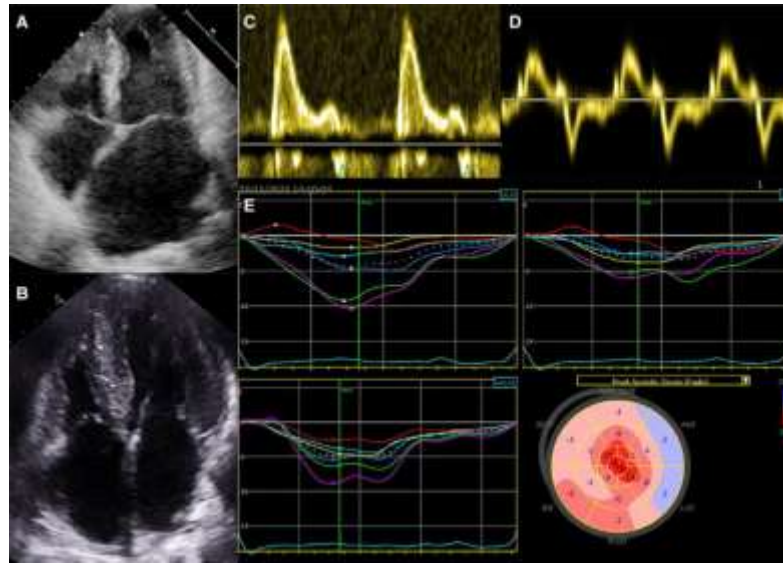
Echocardiography in restrictive cardiomyopathies. (A) Small LV cavity size in presence of significantly increased wall thickness and severe LA dilatation; (B) biventricular wall thickening in absence of pulmonary hypertension; (C and D) restrictive filling pattern with elevated E/E' ratio in keeping with increased LV filling pressures; (E) myocardial strain analysis showing an apical sparing pattern in a patient with cardiac amyloidosis. Source: Rapezzi C, Aimo A, Barison A, et al. Restrictive cardiomyopathy: definition and diagnosis. *European Heart Journal*. 2022 Dec 1;43(45):4679-93.
